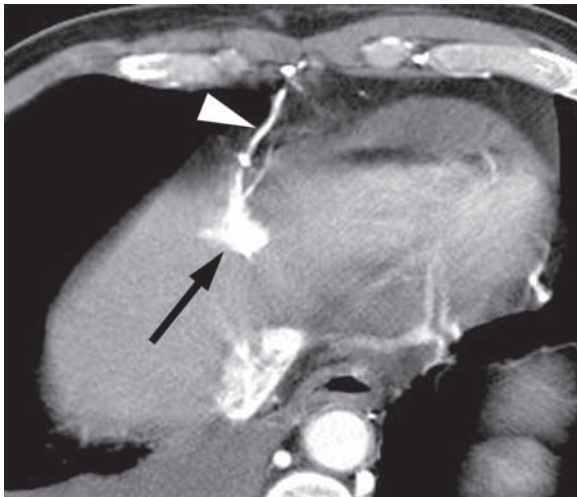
Pseudolesion in segment IV of the liver due to superior vena caval obstruction caused by lung cancer in a 57-year-old man. Arterial phase CT scan shows strong enhancement at the cephalic portion of segment IV (arrow) caused by the direct flow of contrast medium into the liver via the superior vein of Sappey (arrowhead).
